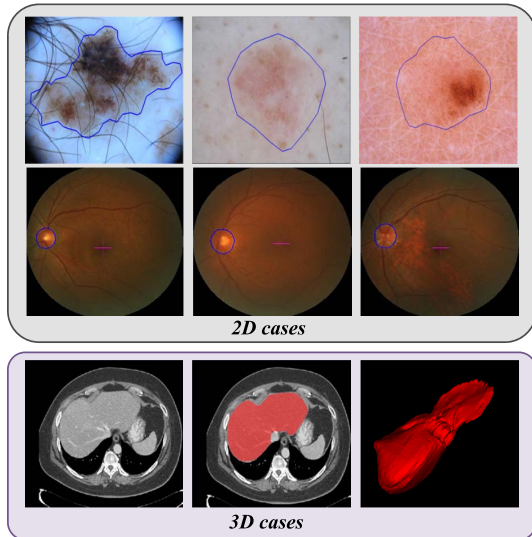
Three common medical image segmentation tasks. The first, second, and third rows show the skin lesion in the dermoscopy image, the OD in retinal fundus images, and liver segmentations from CT scans, respectively. Blue color denotes the structure boundary and red color represents the liver.
